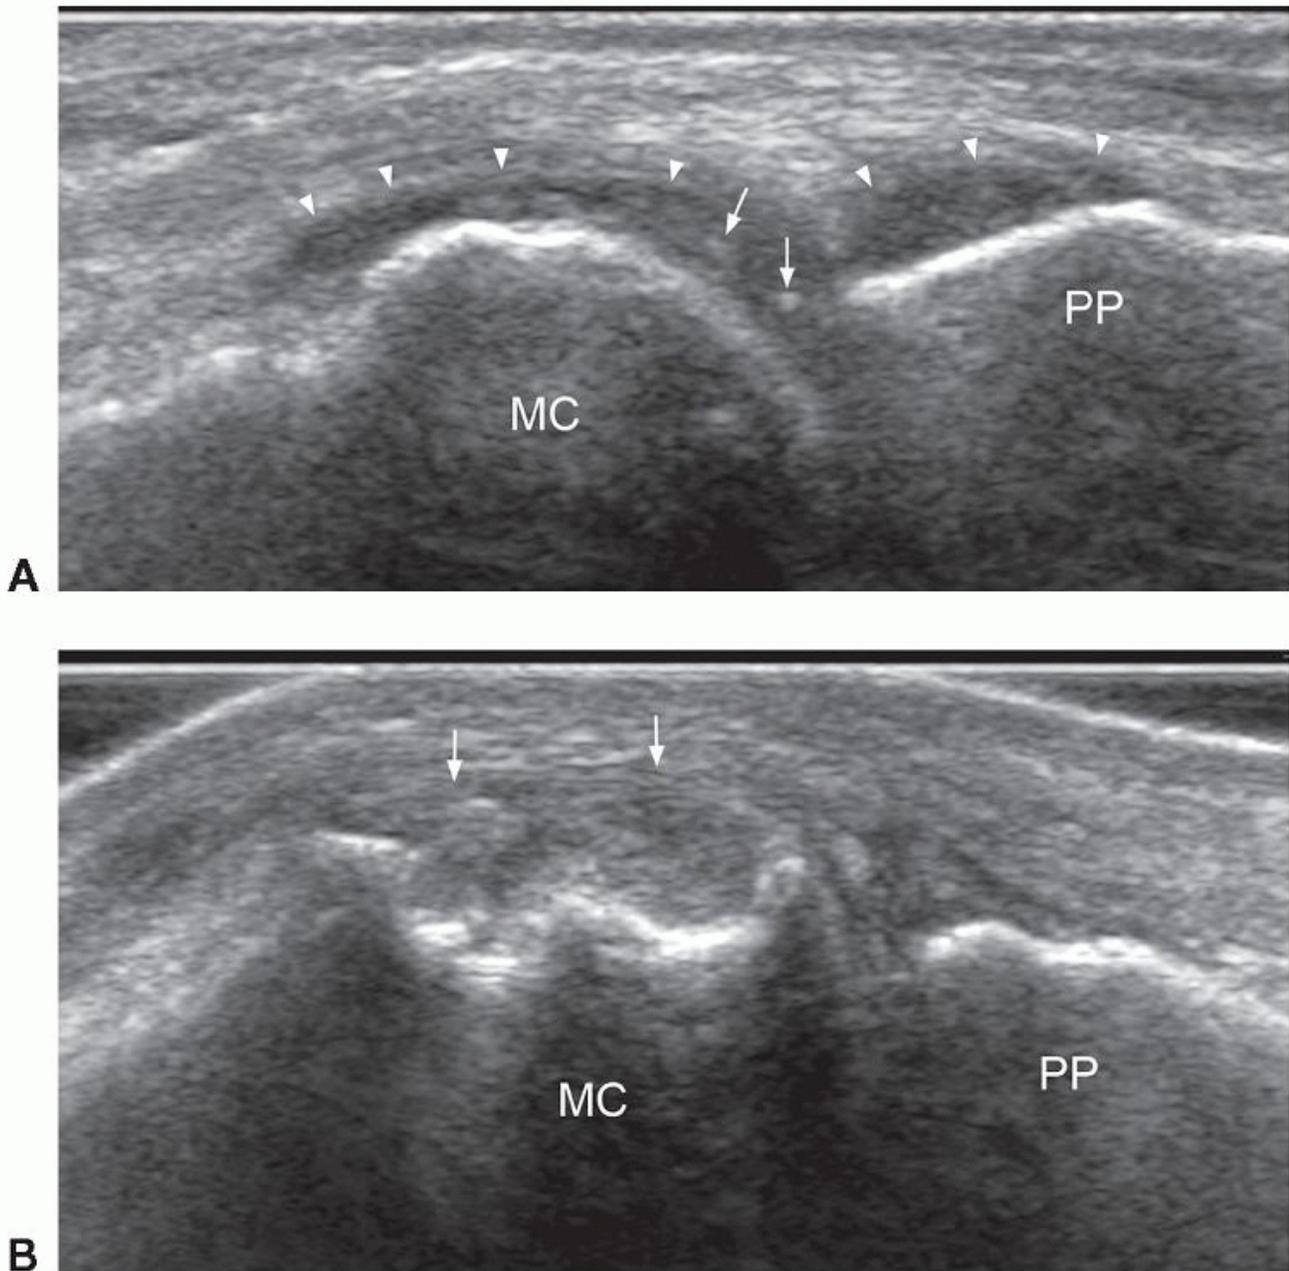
Longitudinal ultrasound of first metatarsophalangeal joint. A: Dorsal aspect of joint showing a small to moderate-sized effusion/synovial proliferation (arrowheads). There are several discrete echogenic foci within the joint consistent with crystal aggregates (arrows). B: Medial aspect of the joint. There is a wide deep erosion (arrows) with overhanging edges consistent with a gouty or crystal arthropathy. MC, metacarpal; PP, proximal phalanx.
